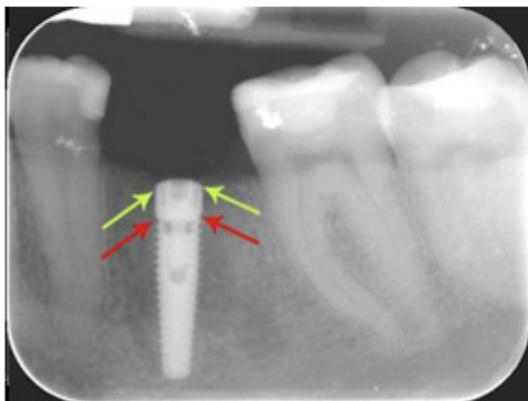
Radiograph documentation of peri-implant bone loss.
